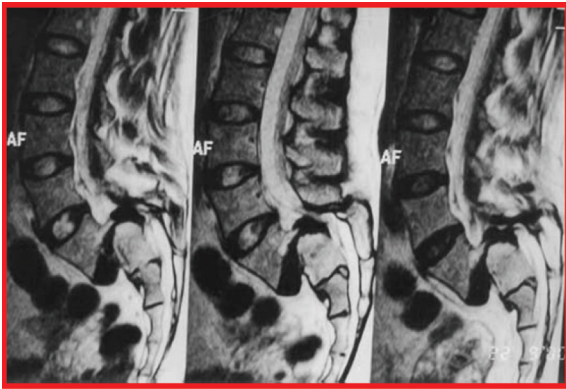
T2 MRI of lumbosacral spine is shown. Disc degeneration and spondyloptosis are noted.
